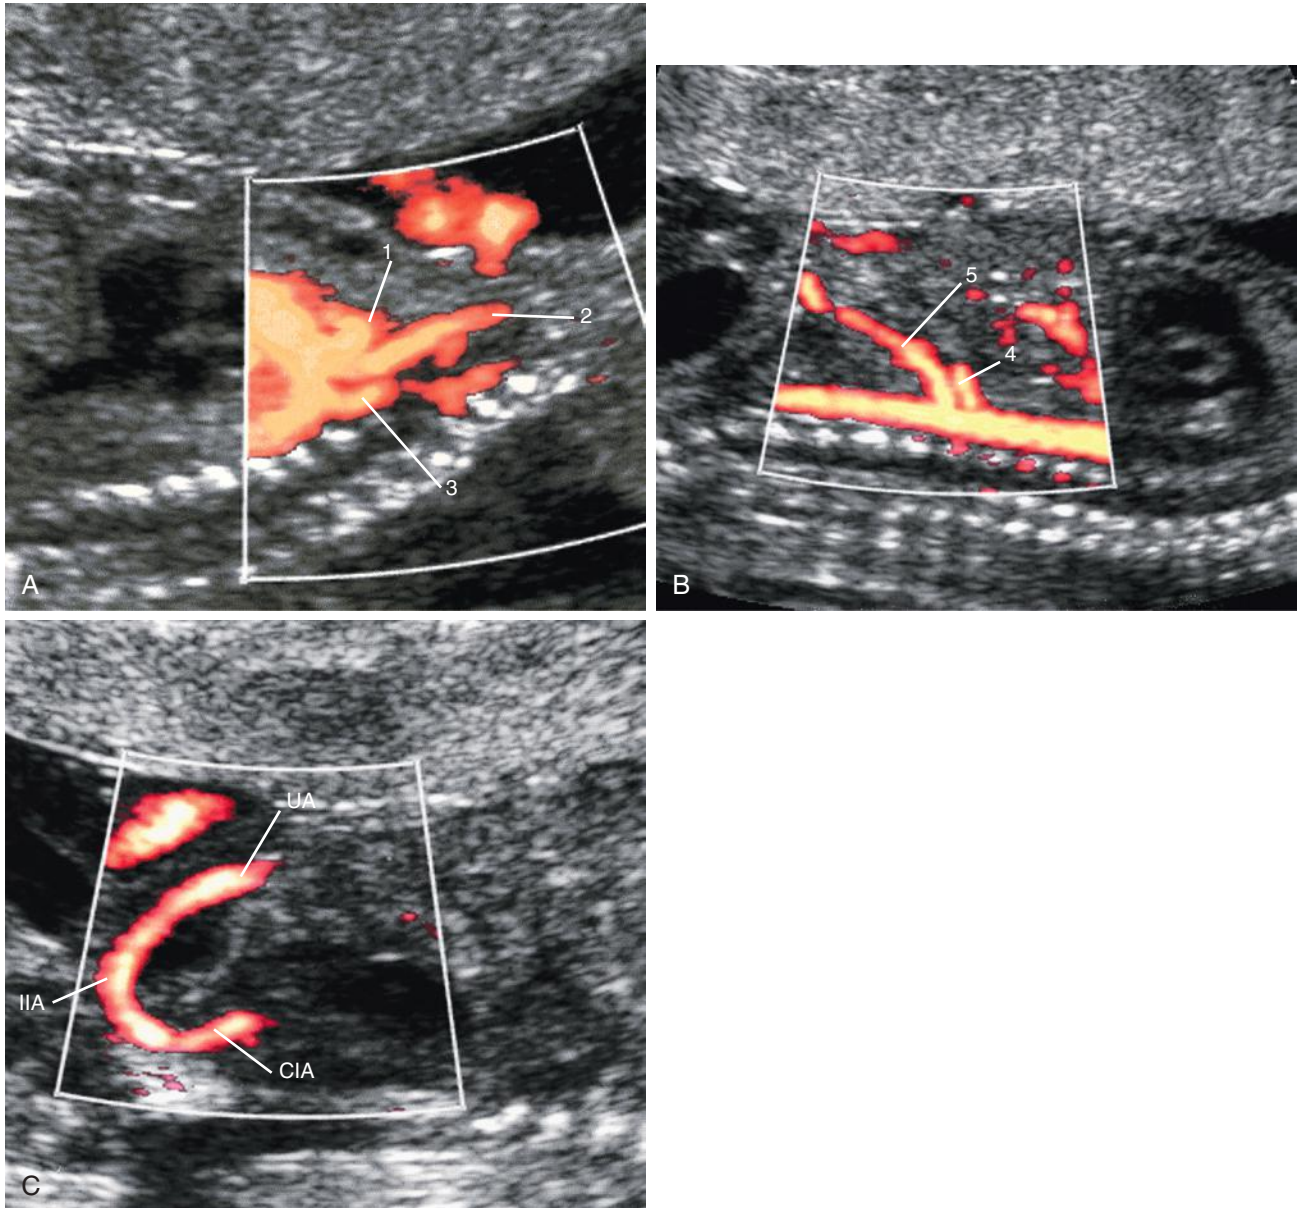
Series of nondirectional color Doppler sonograms of the fetal torso. A, The aortic arch is seen to good advantage. 1, brachiocephalic artery; 2, left common carotid artery; 3, left subclavian artery. B, Midsagittal sonogram of the abdominal aorta. 4, celiac axis; 5, superior mesenteric artery. C, Oblique sonogram through the fetal pelvis demonstrating the umbilical artery (UA) joining the internal iliac artery (IIA) and continuing into the common iliac artery (CIA).
